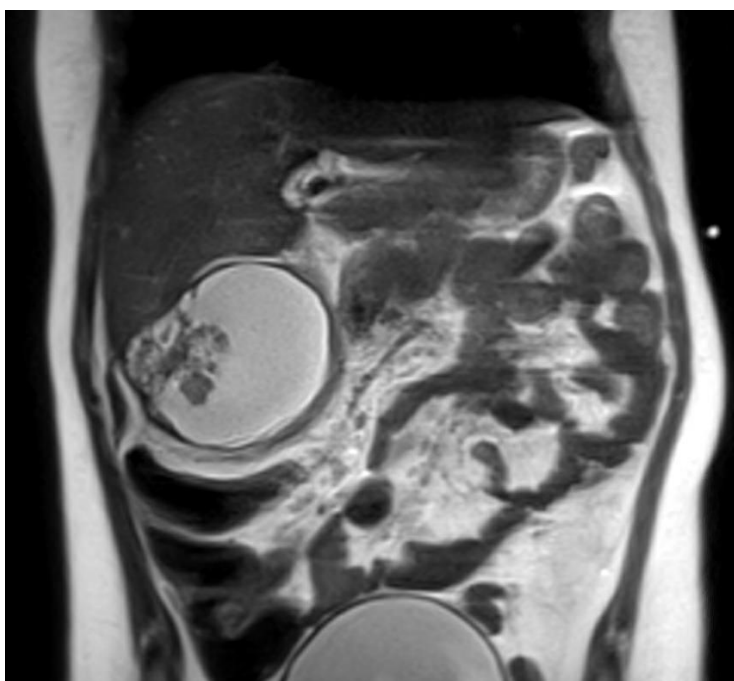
Abdominal MRI images of the child. It shows a mass (polyp) inside the distended gallbladder.
